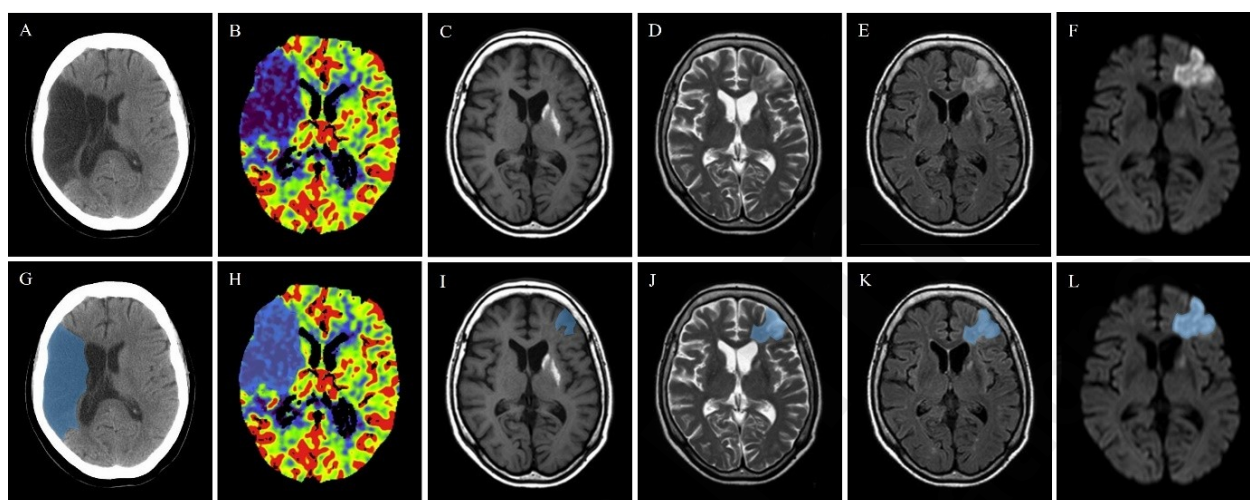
Stroke lesions identified using different imaging modalities. (A)NCCT; (B)CTP; (C)T1WI; (D)T2WI; (E)FLAIR; (F)DWI (G)NCCT (annotated); (H)CTP (annotated); (I)T1WI (annotated); (J)T2WI (annotated); (K)FLAIR (annotated); (L)DWI (annotated). Stroke lesion areas are marked with blue regions and the images are not paired.
